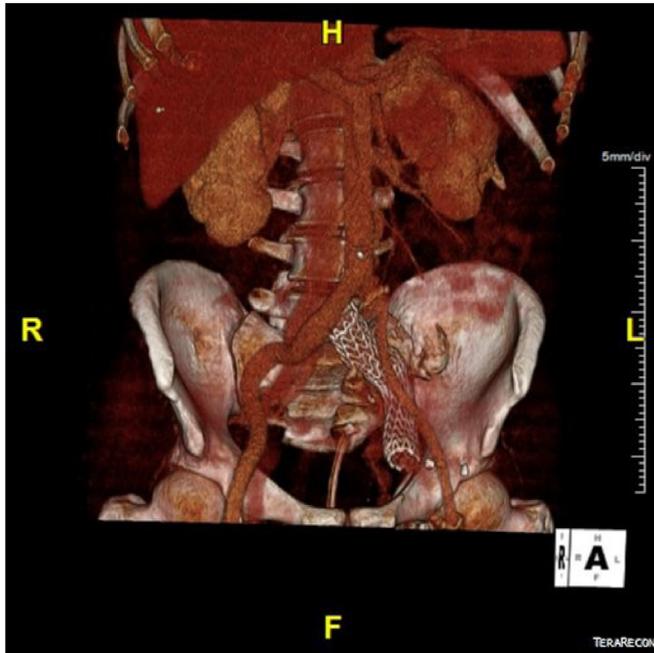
Postoperative computed tomography (CT) scan of a thoracic stent graft placed in an injured external iliac vein. The patient provided written informed consent for the publication of the image.
